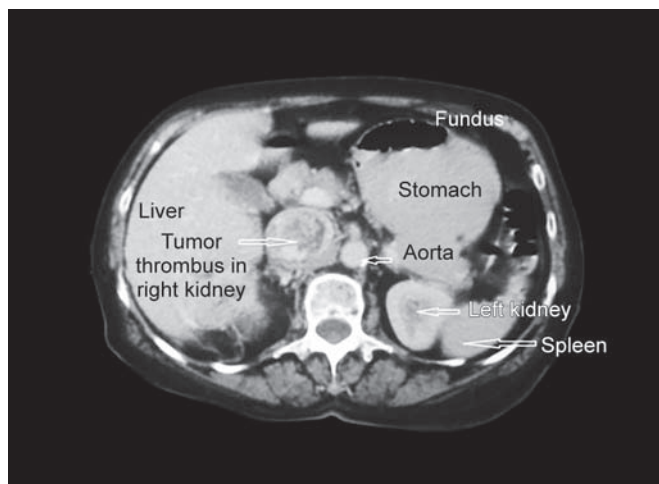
Contrast-enhanced computed tomography showing heterogenous mass in middle and lower lobe of right kidney
